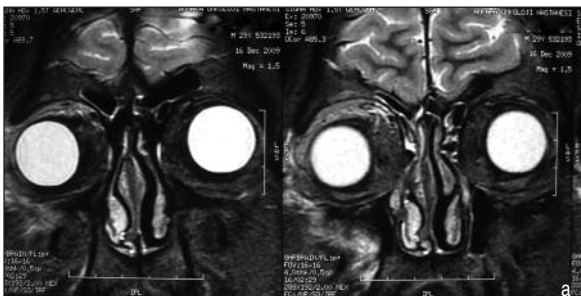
The patient's MRI before FSRT. Orbital MRI showed thickening in retrobulbar muscles and eyelid soft tissue swelling with contrast enhancement in the right orbit with proptosis of the globe.
